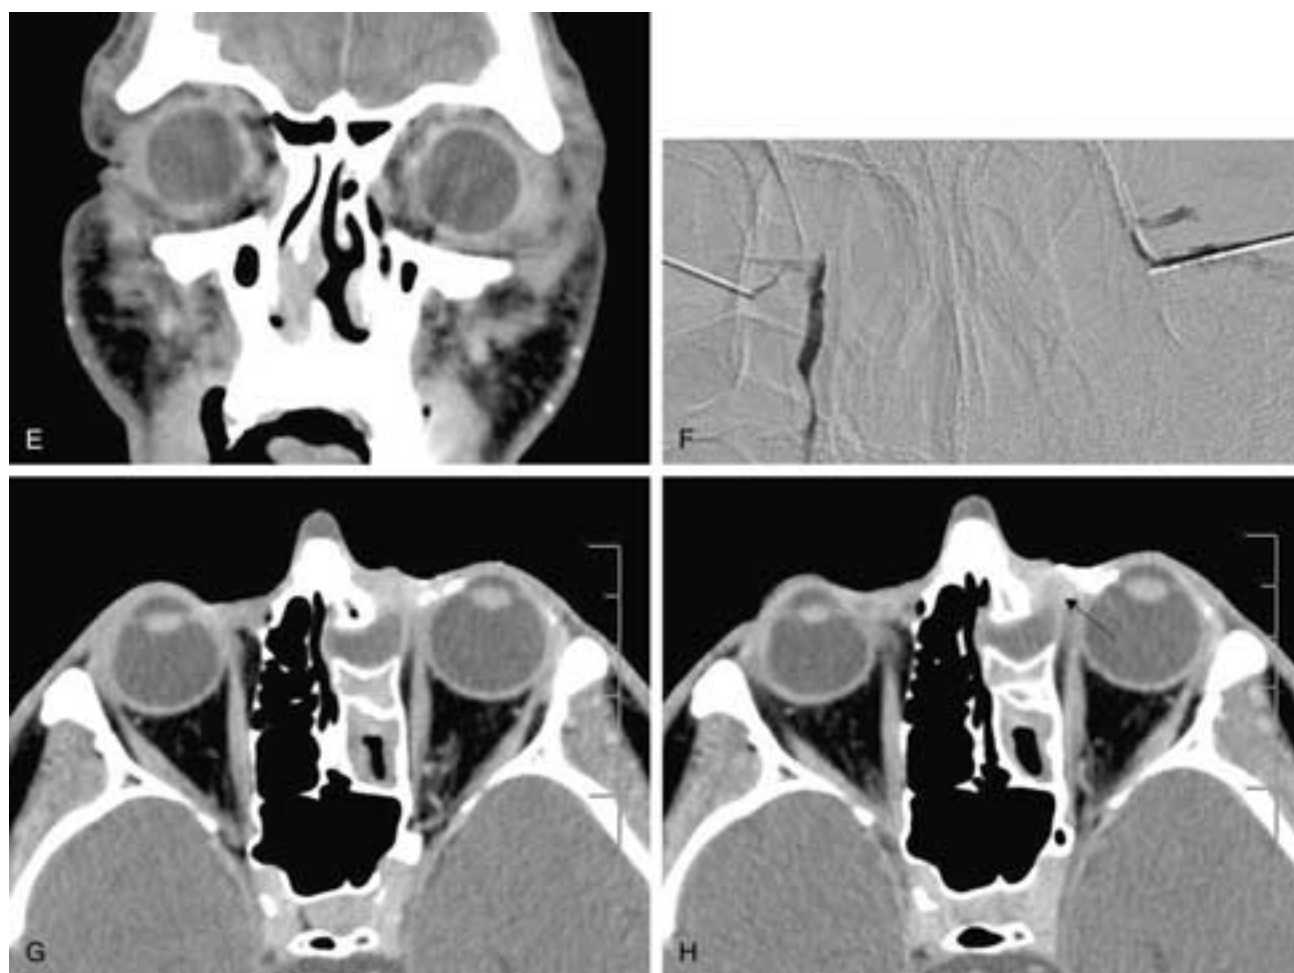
Continued.* F to J, Fourth patient. Anterior ethmoid mucocoele. F, DCG shows blocks at the common canaliculus, with dilatation of the superior and inferior canaliculi suggesting chronic canalicular inflammatory changes. G and H, Axial-enhanced CT scan shows a cystic mass centered within the anterior ethmoid air cell and projecting into the lacrimal sac fossa. Soft-tissue swelling of the left inner canthus and enlarged lacrimal sac (arrow).
